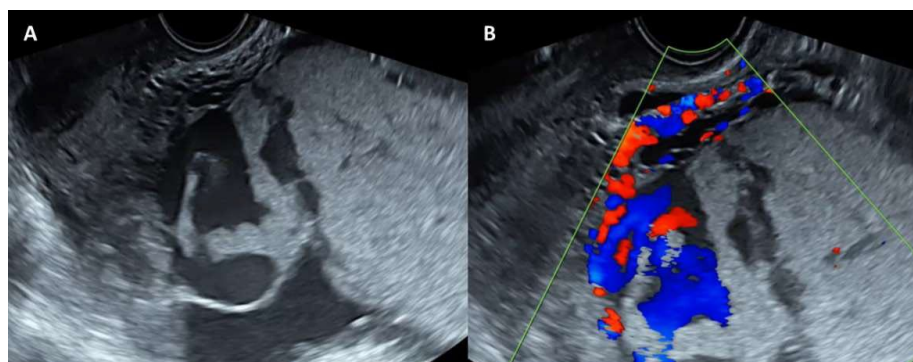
Large and irregular vascular lacunae (A). With Colour Doppler (B), high velocity turbulent flow is observed.
